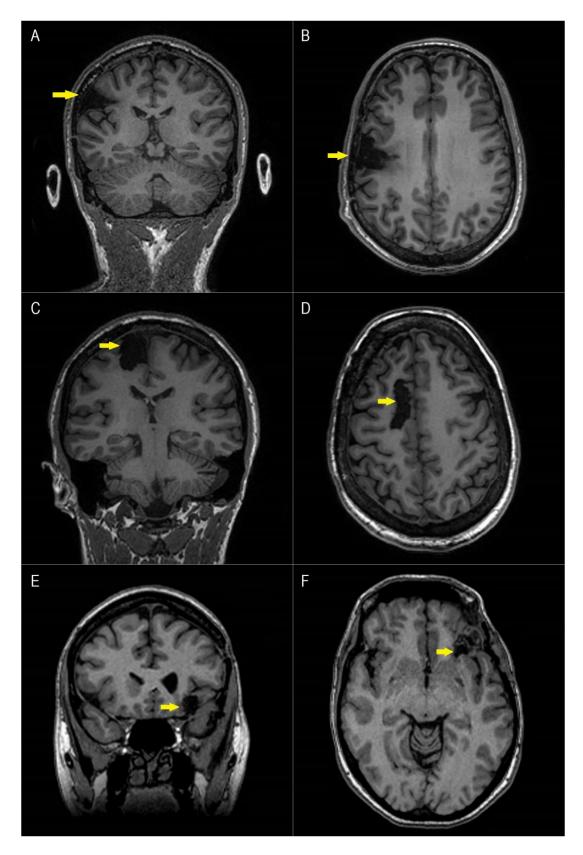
Imaging categorisation example. Right dorsolateral resection in coronal (A) and axial (B) views. Right frontomedial resection in coronal (C) and axial (D) views. Left orbitofrontal resection in coronal (E) and axial (F) views. All images are T1-weighted 3T MRI sequences; yellow arrows indicate site of resection.
